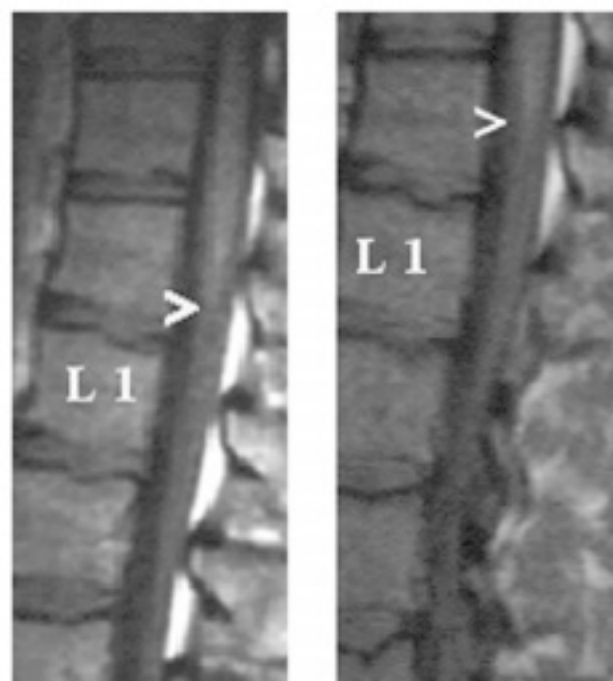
Case 2. The preoperative lumbar MRI shows the conus medullaris at the inferior edge of D12 (left). In the postoperative MRI, the conus is seen at the middle of D12 vertebral body
